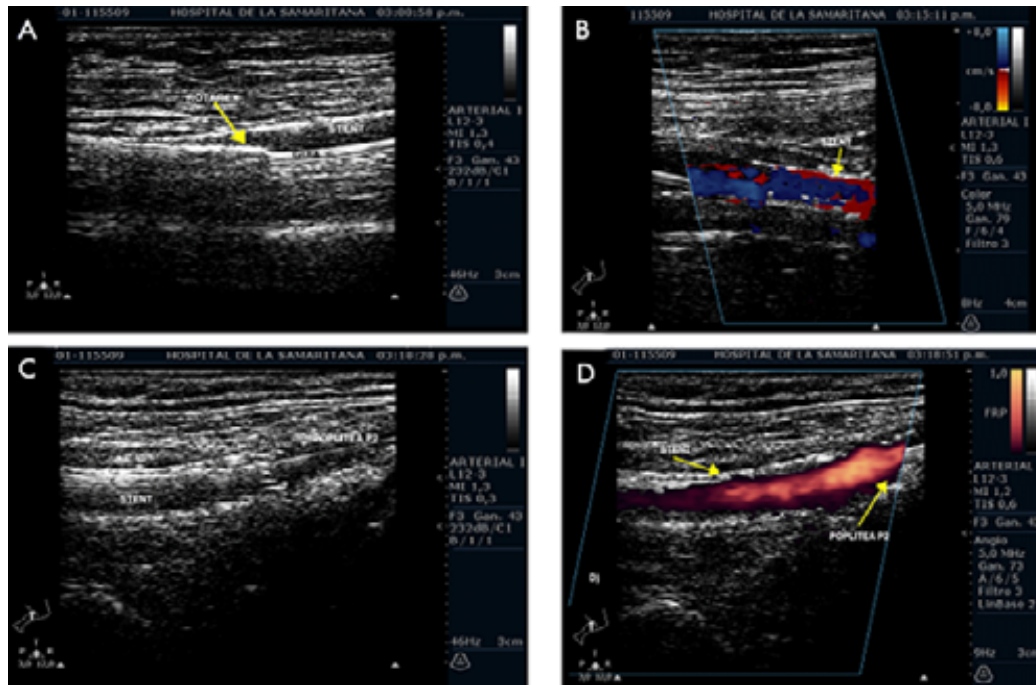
Ultrasound-guided endovascular mechanical thrombectomy and postoperative management. A) passage of mechanical thrombectomy system over support guidewire through the blocked stent; B) and C) 2D and color duplex with confirmation of previously occluded stent permeabilization; D) color duplex showing adequate stent patency and second segment of the popliteal artery in the immediate postoperative period.
